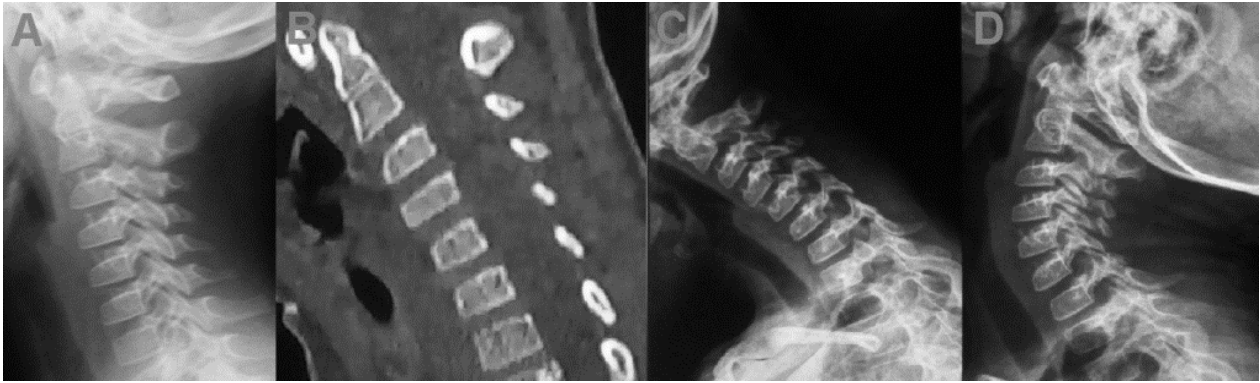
A: simple spine X-Ray. B: cervical spine CT (bone window). C: Dynamic X-Ray on flexion. D: Dynamic X-Ray on extension; those images showed a straightening of the cervical spine without bone lesions or instabilities.
